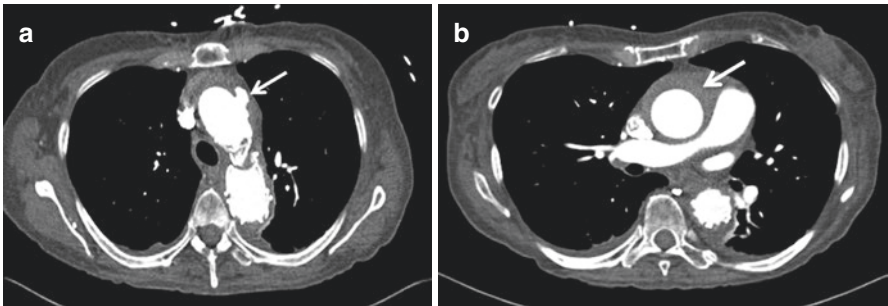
Patient with a retrograde type A IMH who presented 4 weeks after a TEVAR for chronic type B aneurysm with CT scan demonstrating the entry tear (a: arrow) and extensive IMH (b: arrow)
